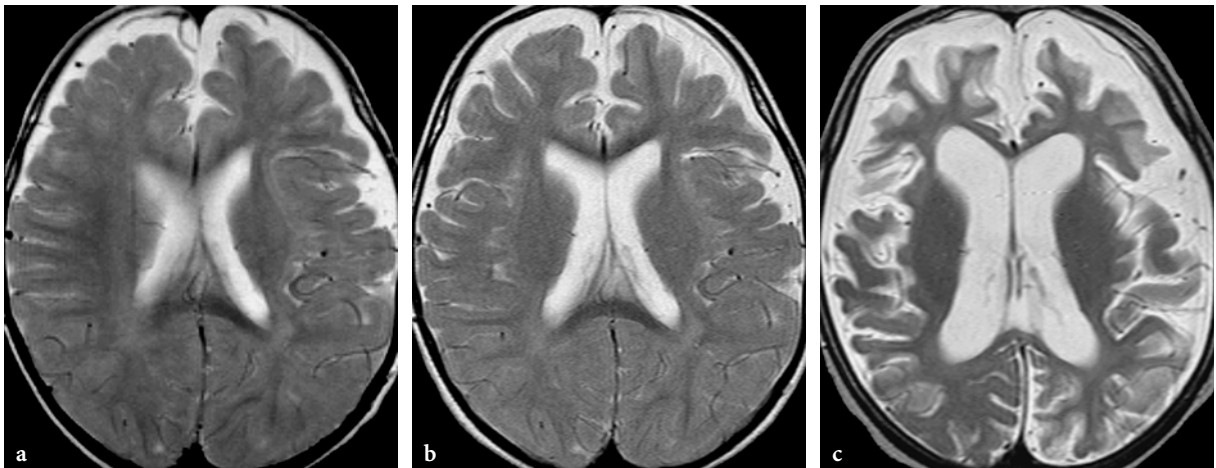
Progressive cerebral atrophy in a male patient with biotinidase deficiency. Axial T2-weighted fast spin echo images. a The initial MR imaging study at the age of 1 year shows mild, predominantly frontal brain atrophy. b First follow-up examination at the age of 2 years. Interval progression of the atrophy. c Second follow-up study at the age of 4 years. Very prominent cortical-subcortical brain atrophy
